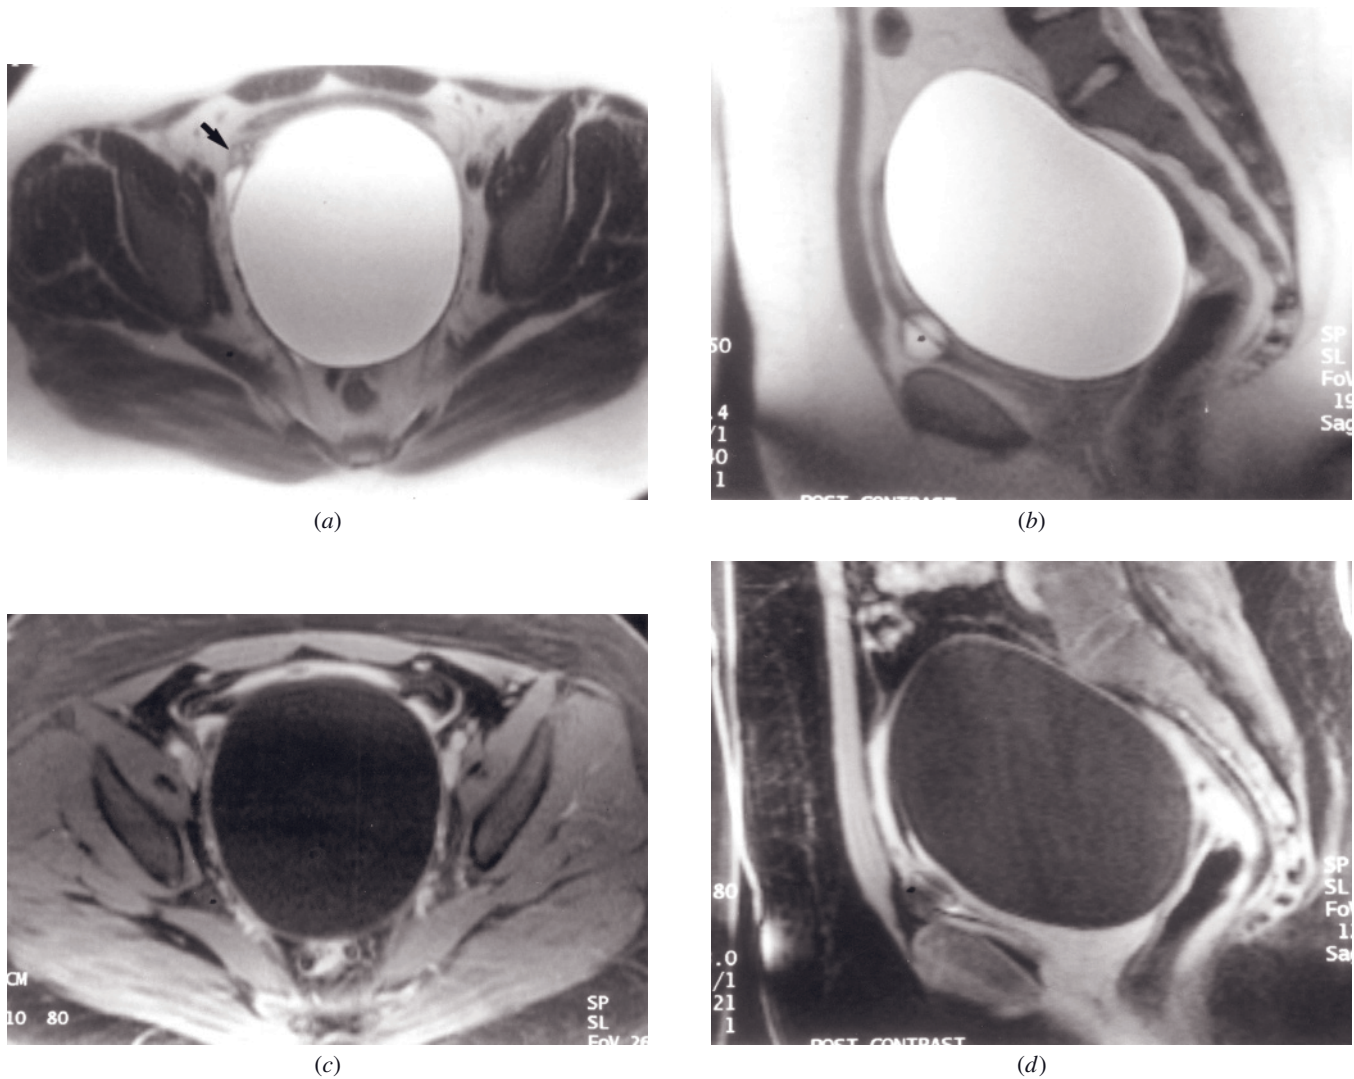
Ovarian cyst. Transverse (a) and sagittal (b) T2-weighted SS-ETSE and transverse (c) and sagittal (d) gadolinium-enhanced fat-suppressed images. A large, well-defined cyst with simple fluid content and no mural irregularity is apparent arising from the right ovary (arrow, a).
